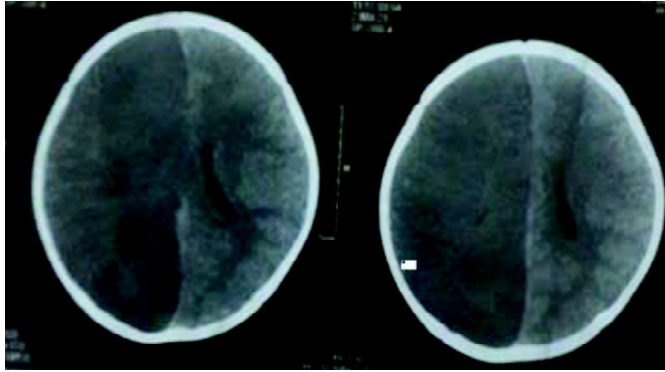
Axial section of CT-brain plain, showing hypodensity over right ICA territory. (A case of post-varicella infection large vessel arteriopathy)
